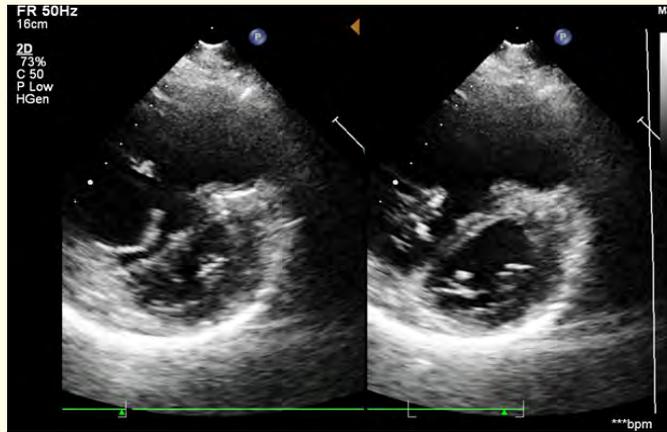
Transthoracic echocardiography showing D-shaped interventricular septum in systole and diastole, which are signs of right ventricular pressure overload and volume overload.
